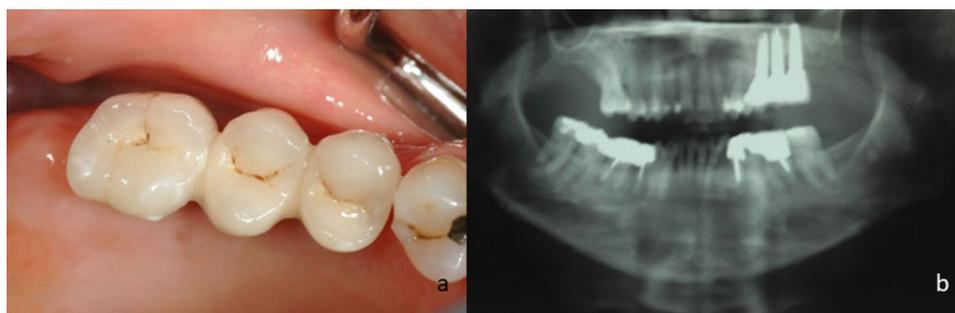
Final rehabilitation a: Clinical photography b: Panoramic x-ray
